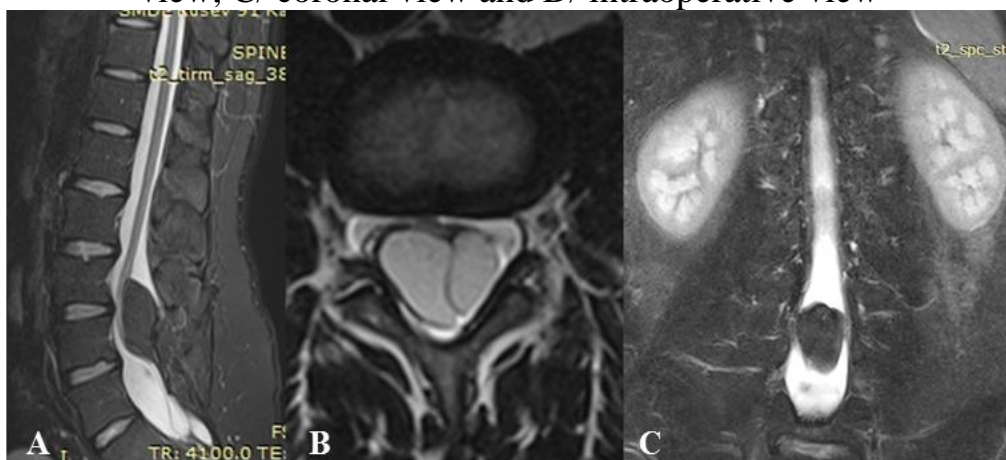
MRI image of intradural lipoma at L₃ - L₄ level: A/ sagittal view; B/ axial view; C/ coronal view
